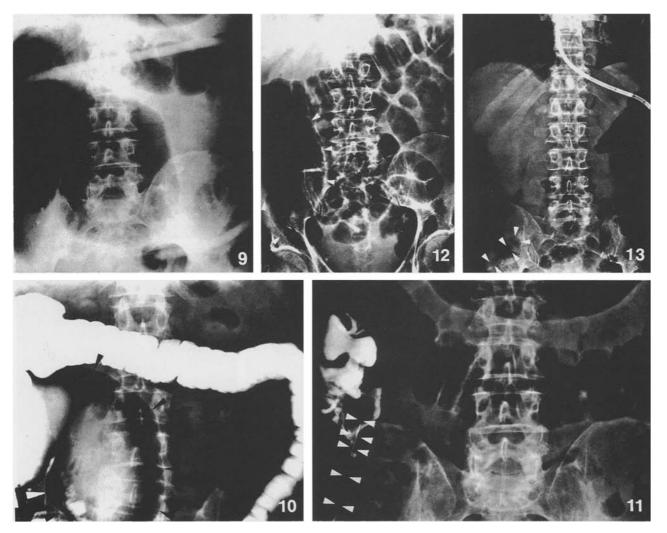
Set of bougie and catheter being drawn through the colon (X-ray of case 1)
